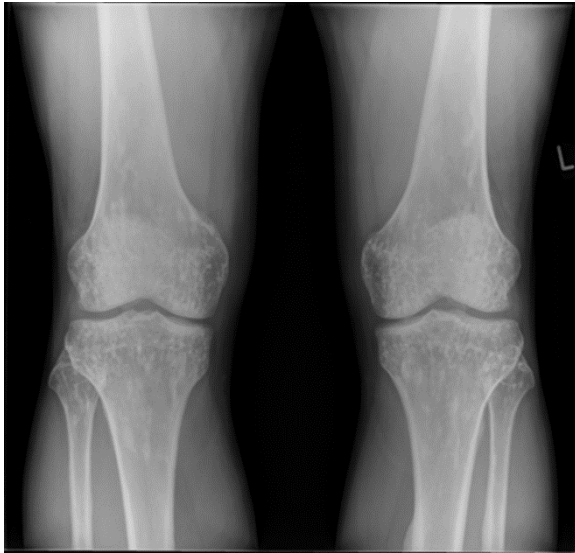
AP radiographs of both knees.
